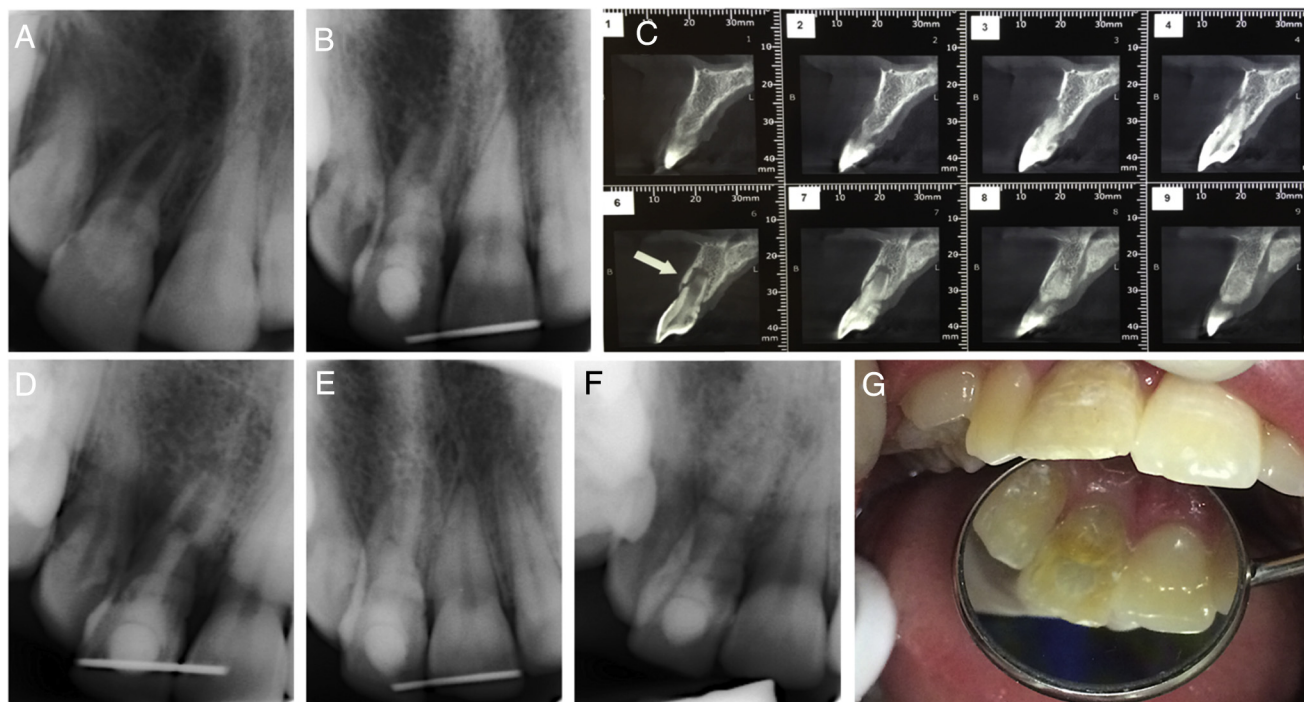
(A) A radiographic view of a right lateral incisor with the diagnosis of dens invagination. (B) The 1-month follow-up revealed progression in root development. (C) The preoperative radiographic examination (cone-beam computed tomographic imaging) revealed an immature tooth with an open apex and labial bone resorption (*arrow* in the 6th section). (D and E) The 3- and 6-month follow-ups showed thickening of the dentinal walls and apical closure. (F) The 18-month follow-up indicated further apical closure dentinal wall thickening. (G) The 18-month follow-up also showed minimal discoloration.
